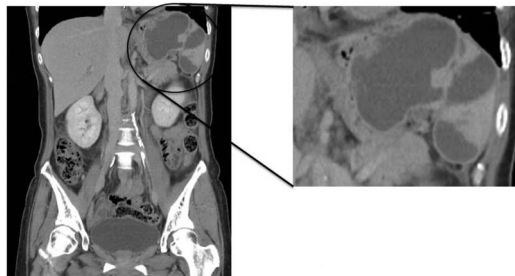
Abdominal contrast-enhanced CT demonstrated loculated splenic collections with thick enhancing walls (figure 1) suspicious for abscess.
